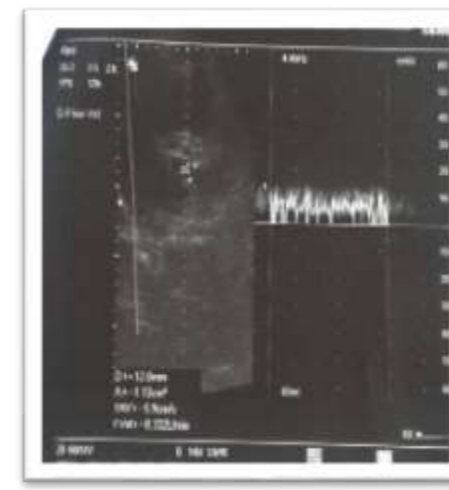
"Doppler of portal vein after statin therapy"
